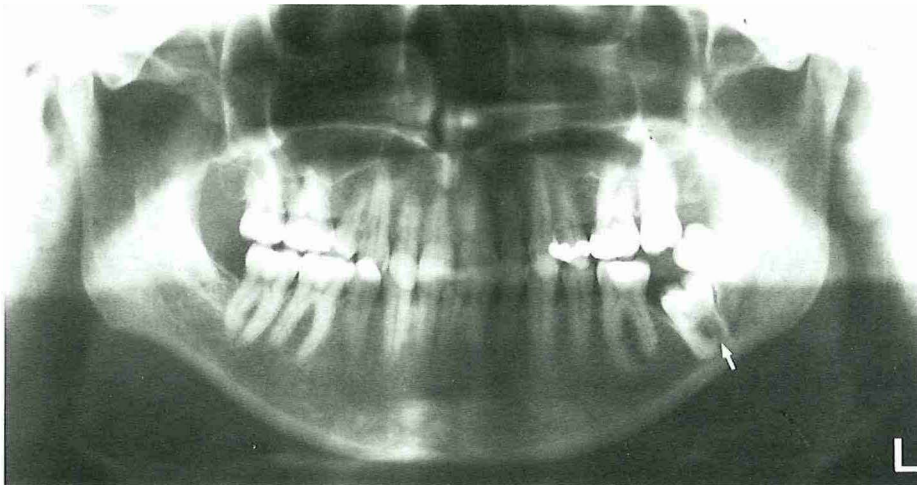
Orthopantomogram of a 34-year-old female with secondary retention of the mandibular left second molar. The margin of the alveolar bone followed the cemento-enamel junction. The distal root of the retained molar shows signs resorption (arrow) which was proven after removal.
